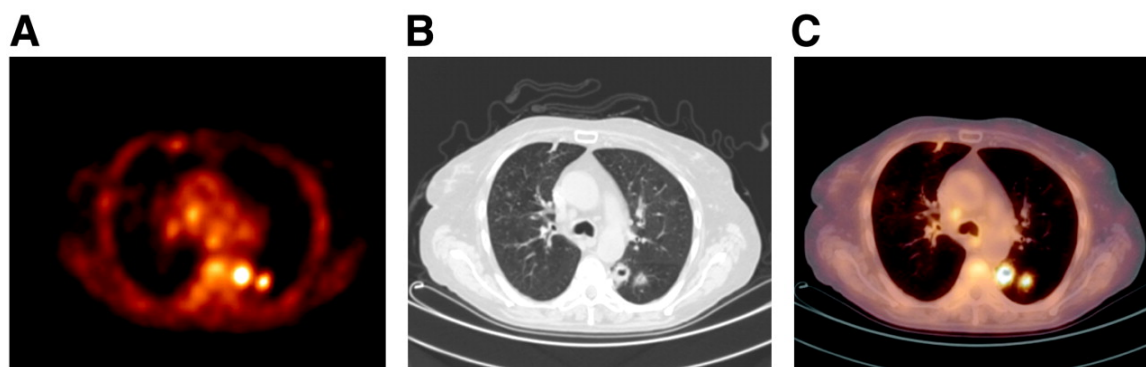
PET image shows more than the real metabolically active part of the tumor because of partial volume effects³⁴². A) PET image. B) Corresponding CT image. C) PET/CT image. Discrepancy between tumor contours as seen on CT and PET images is clearly visible.
